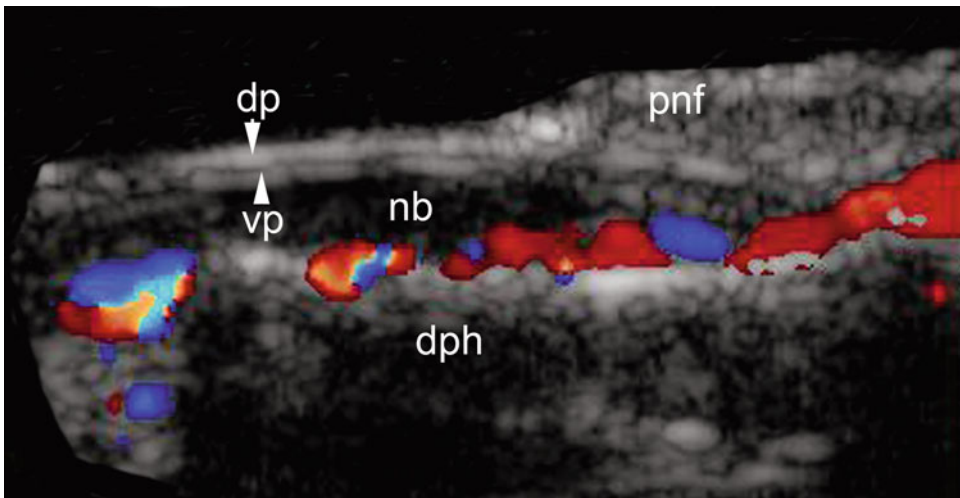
Ultrasonography with color Doppler (Courtesy of Ximena Wortsman, Chile)
